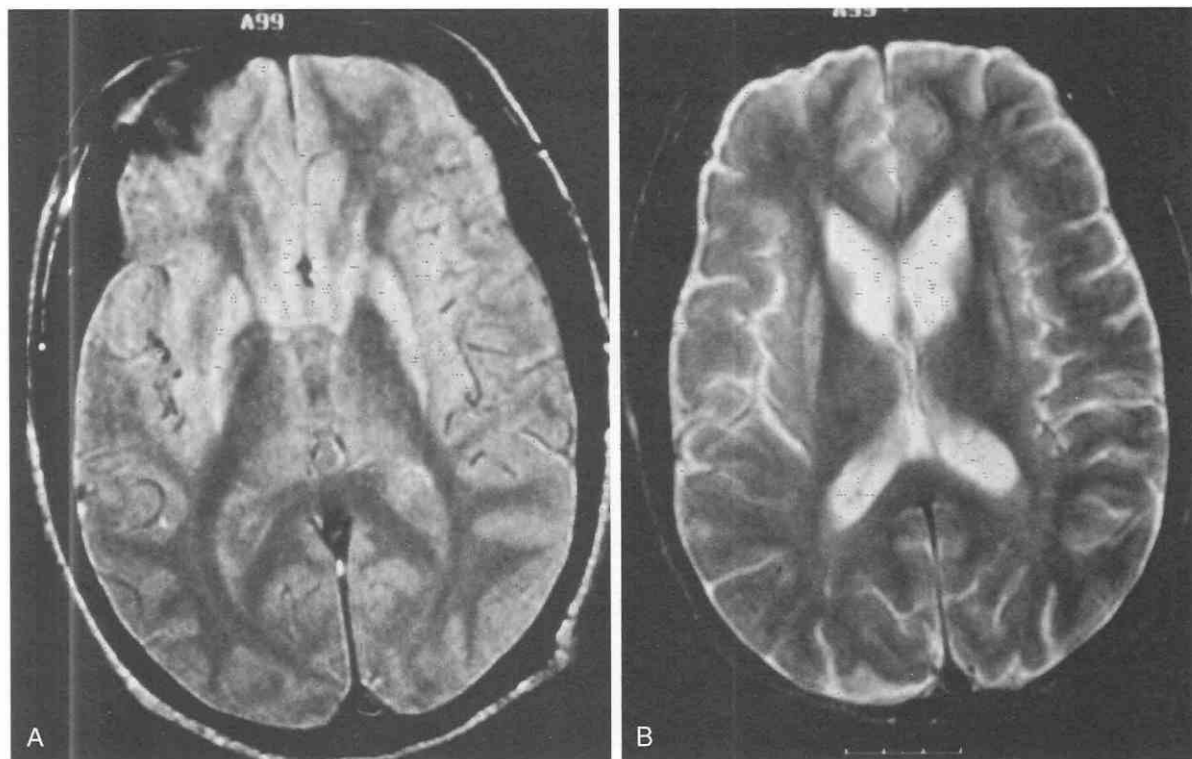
Huntington's disease in a 33-year-old man. Axial proton-density (A) and T2-weighted (B) images demonstrate abnormal signal intensity in the putamen and caudate nuclei. (From Sclar G, Kennedy CA, Hill JM: Cerebellar degeneration associated with HIV infection [letter]. *Neurology* 54:1012-1013, 2000.)
